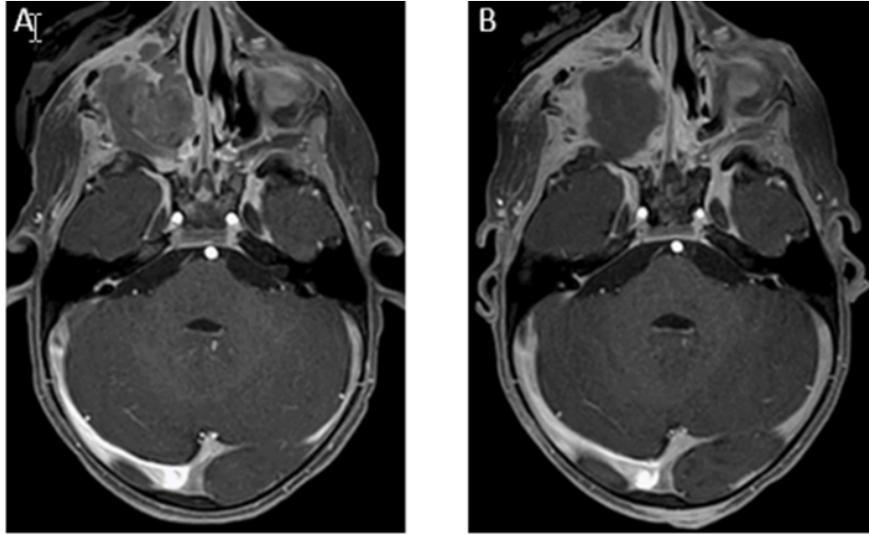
(A) MRI of recurrent tumor in the right orbit. (B) MRI follow-up after 6 weeks, which showed decrease in tumor size and extensive necrosis.
